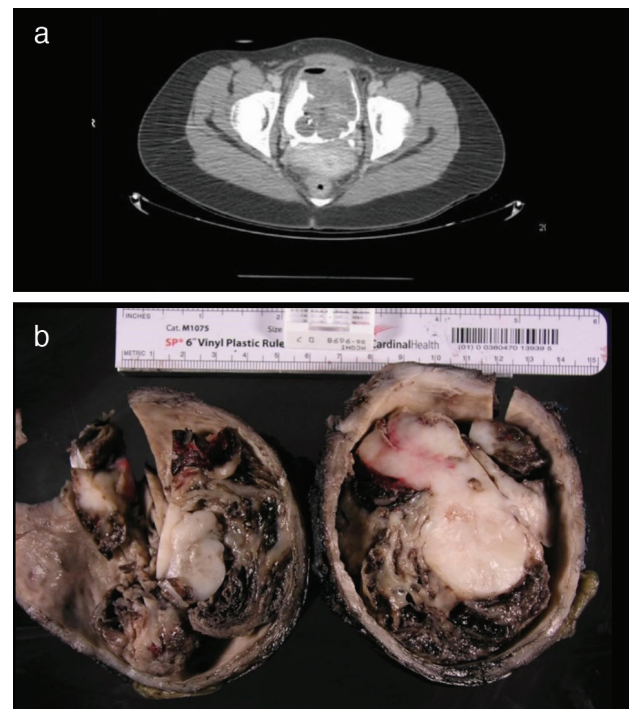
a) Computed tomography with intravenous contrast (transverse section), demonstrating a large volume, complex bladder mass; b) Anatomic gross representation of the bladder (bivalved) showing necrotic and viable portions of tumor, measuring 7.1x6.5x3.9 cm
